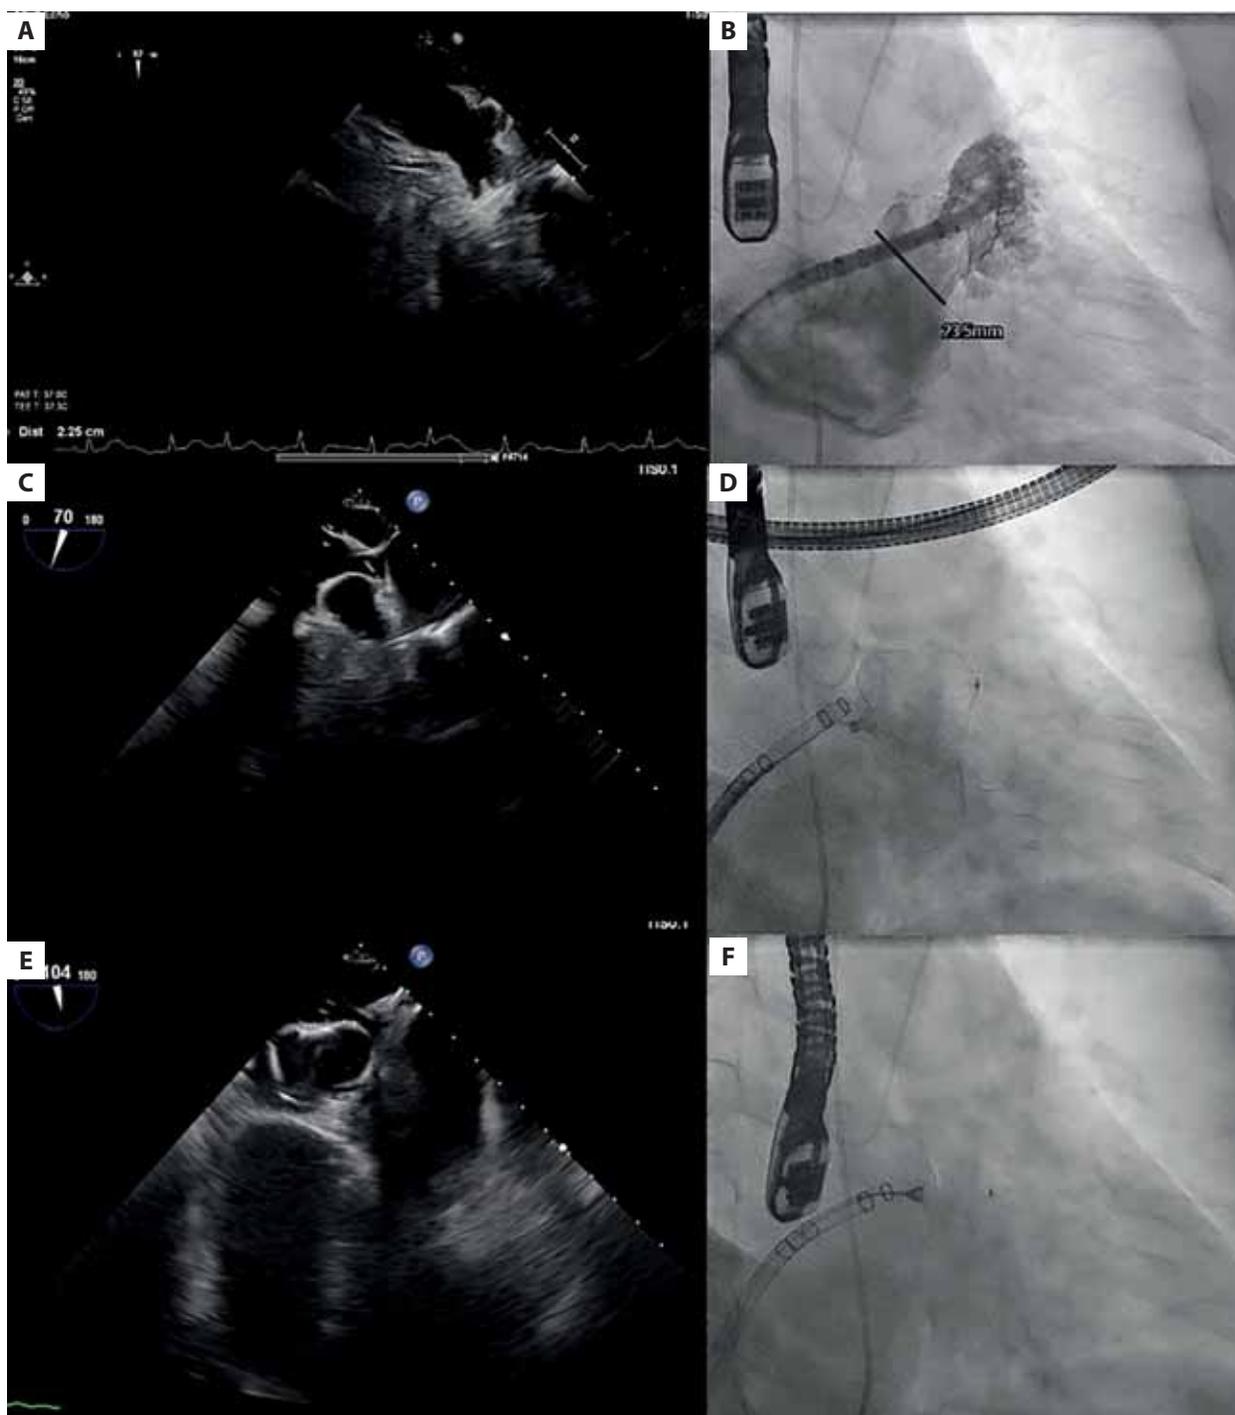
Pre-procedure measurements: (A) transesophageal echocardiogram (TEE) showed a landing zone of 20×23 mm while (B) fluoroscopy suggested a diameter of 24 mm. (C) The 35-mm Watchman FLXTM device fulfilling the PASS (Position, Anchoring, Size, Seal) criteria on TEE. (D) After releasing, the device moved to the left auricle in a perpendicular position to the left atrial appendage (TEE). (E) Several attempts were made to remove the device, but only after using gastroenterological forceps, the device was captured and safely removed. (F) A 31-mm Watchman FLXTM was deployed, with complete sealing and no further complications
